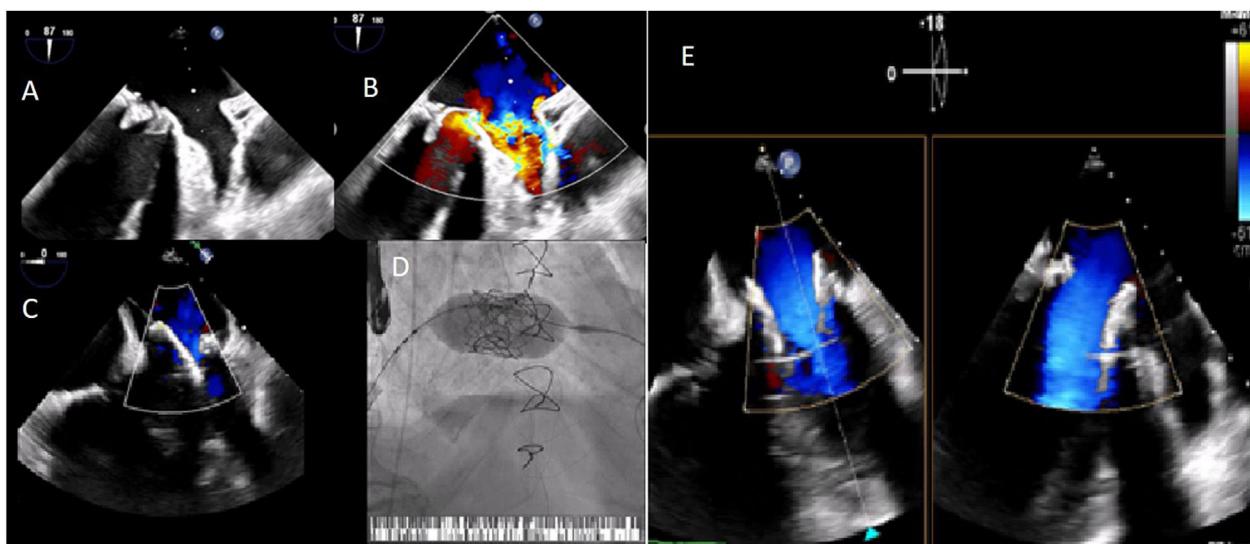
(A and B) Severe mitral prosthesis regurgitation due to cusp prolapse, jets directed posterior-laterally and to the left atrial appendage; implantation of an Edwards Sapiens 3 Ultra-29 valve, with transesophageal echocardiography (C) and fluoroscopy (D) guidance; (E) final result: no signs of interference in the adjacent cardiac structures; a small lateral peri-prosthesis leak was observed.
